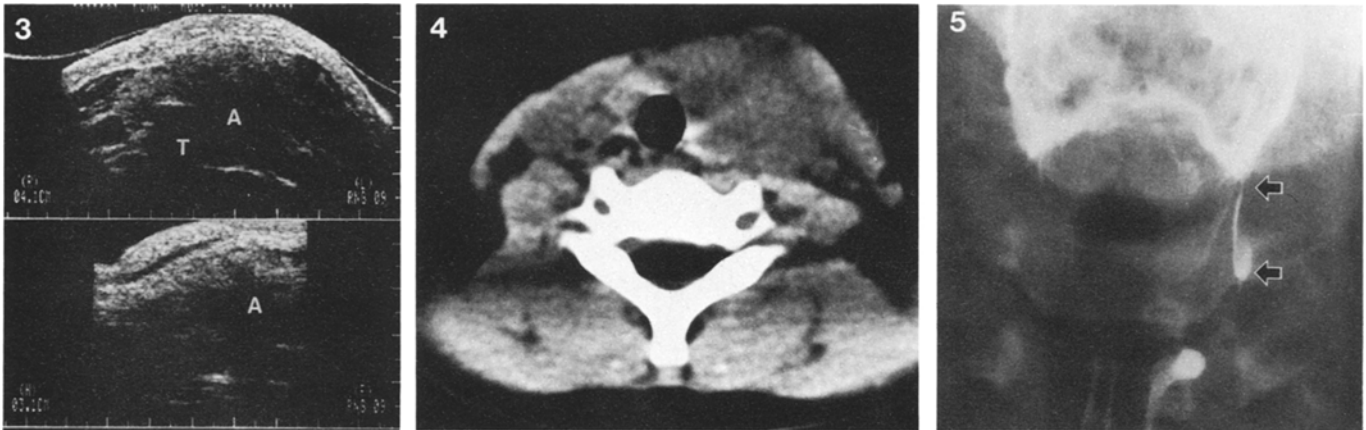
Ultrasonography demonstrates an abscess in and around the left thyroid lobe in a patient with acute suppurative thyroiditis. Upper: Horizontal scan. Lower: Sagittal scan. A: Indicates abscess, T: Trachea.
